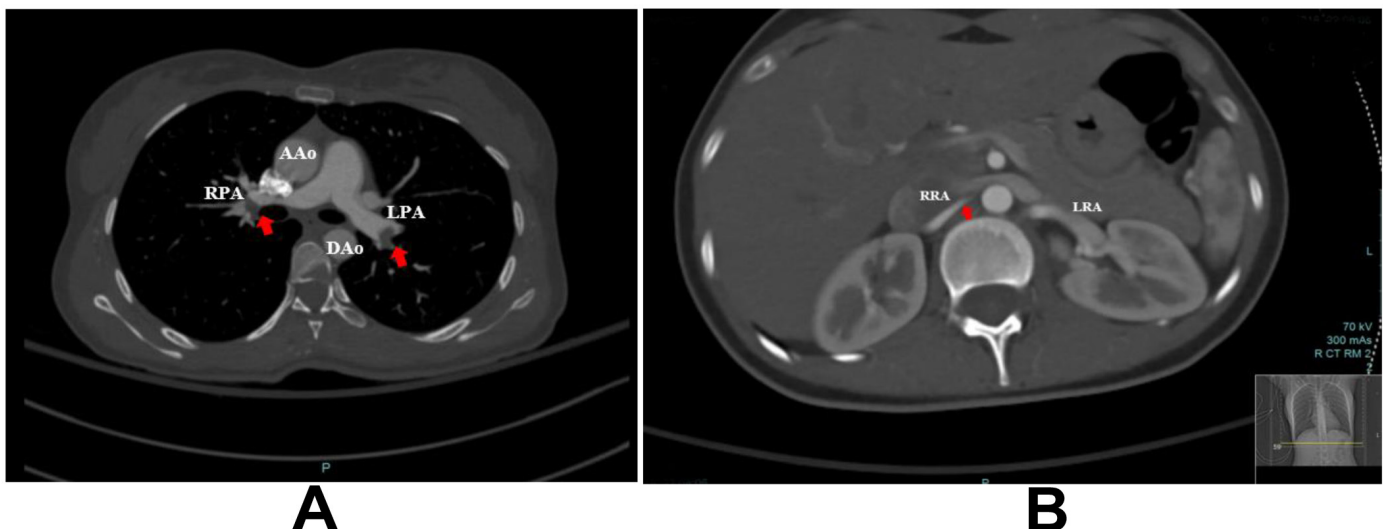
A. Computed tomography (CT) scan, PE study with axial cut showing distal filling defects in right and left pulmonary arteries (red arrows) RPA and LPA. B. Right renal artery with partial occlusion likely thrombus.
